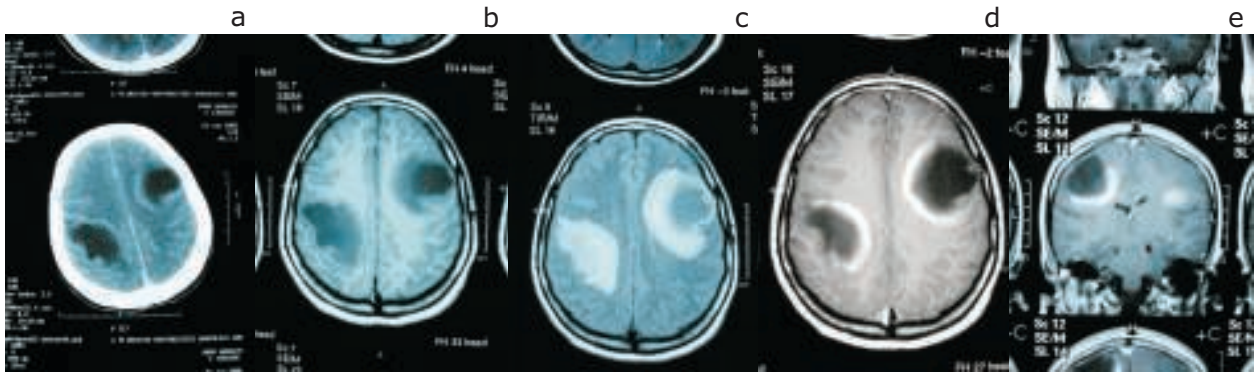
CT view before treatment (a), T1 axial MR image prior to surgery (b), T2 flair view (c), contrast axial (d) and coronal (e) view.
